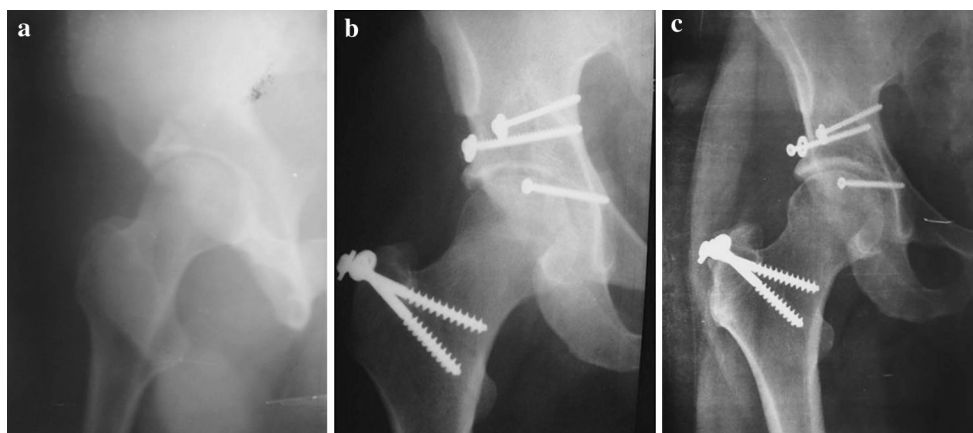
a Preoperative anteroposterior (AP) radiographs of a 40-year-old man showing posterior acetabular-wall fracture, b postoperative AP radiograph showing anatomical reduction, c AP radiographs at 22 years' follow-up showing excellent radiological outcome
